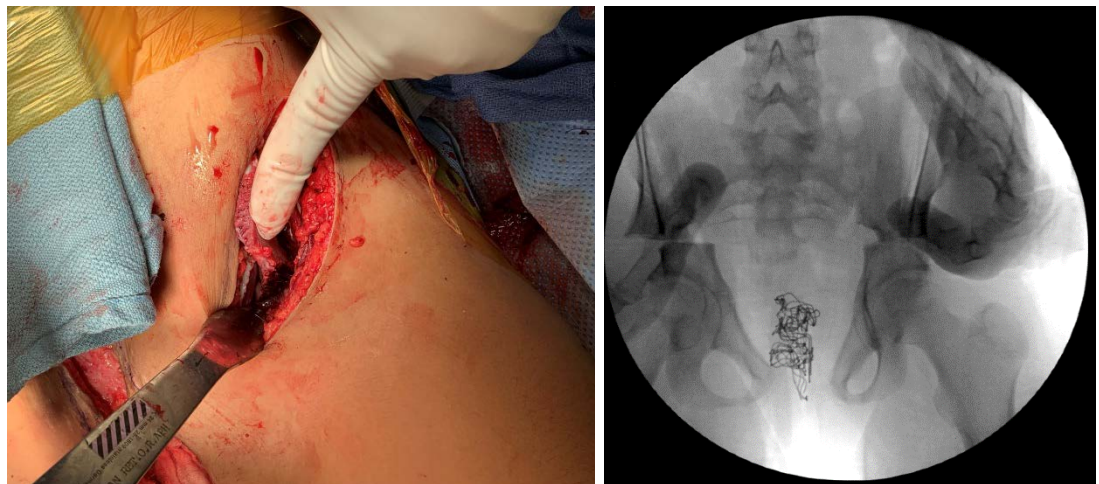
Clinical (A) and radiographical (B) demonstrations of vertical unicortical posterior osteotomies of the iliac wings (black arrows)
